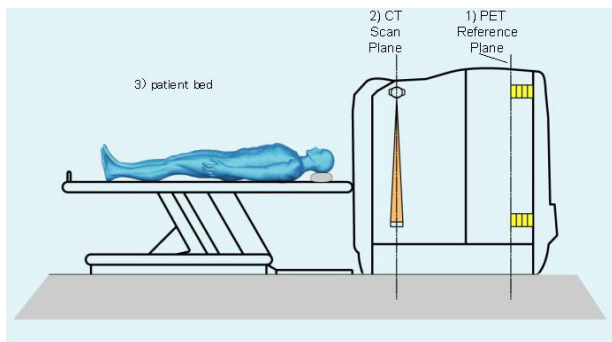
Basic PET/CT scanner design.
